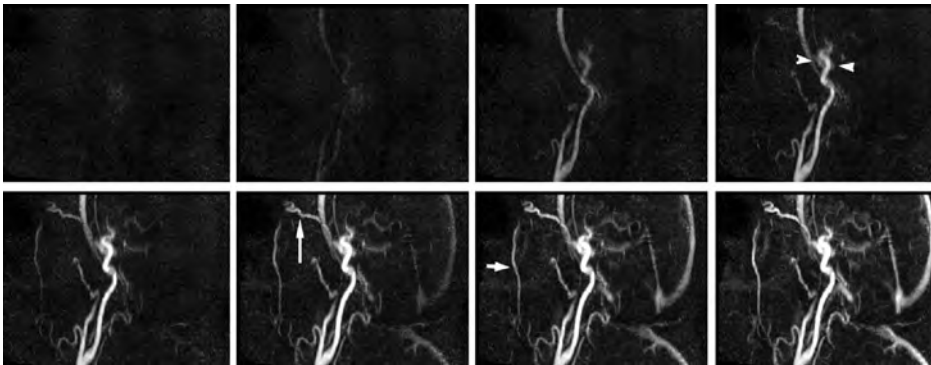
syngo* TWIST for an indirect cavernous-carotid fistula (CCF). The images had adequate spatial and temporal resolution to demonstrate a "blush" in the region of the cavernous sinus (arrowheads) including clear early filling of the superior ophthalmic vein (SOV, long arrow) and facial vein (short arrow) several seconds before filling of the superior sagittal sinus. The vascular anatomy and flow dynamics demonstrated by the MRI/MRA obviated the need to perform a diagnostic angiogram. Courtesy of Srinivasan Mukundan, Jr, PhD, MD, Duke University Medical Center, North Carolina, USA.
